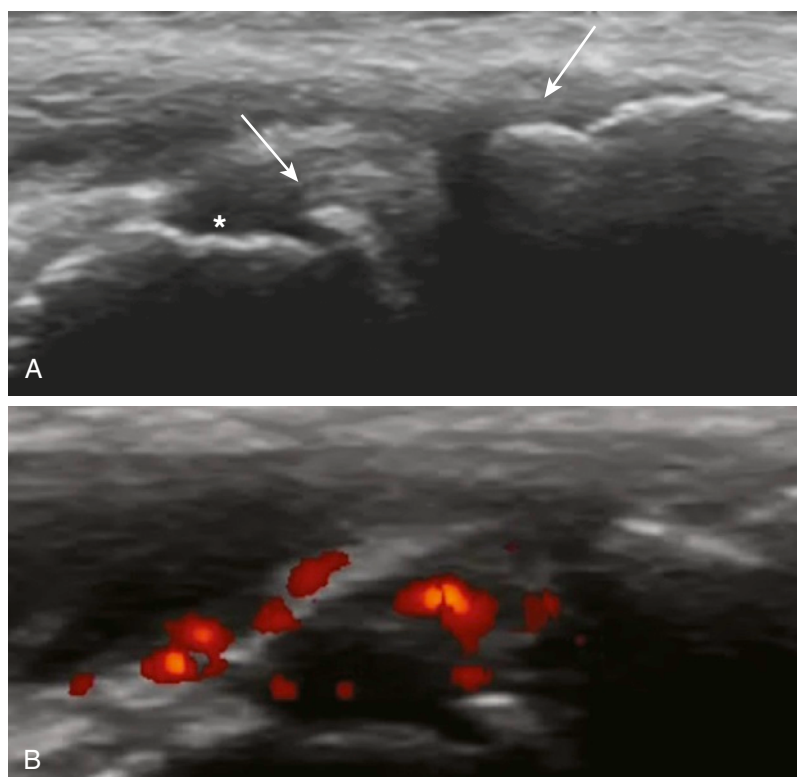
Ultrasound is used to assess the first carpometacarpal joint in a patient with hand osteoarthritis. A, The gray-scale, longitudinal, 15-MHz image of the joint demonstrates a joint effusion (*star*), synovial hypertrophy, and osteophytes (*arrows*). B, Power Doppler technique shows increased perfusion within the synovial tissue due to active inflammation.
